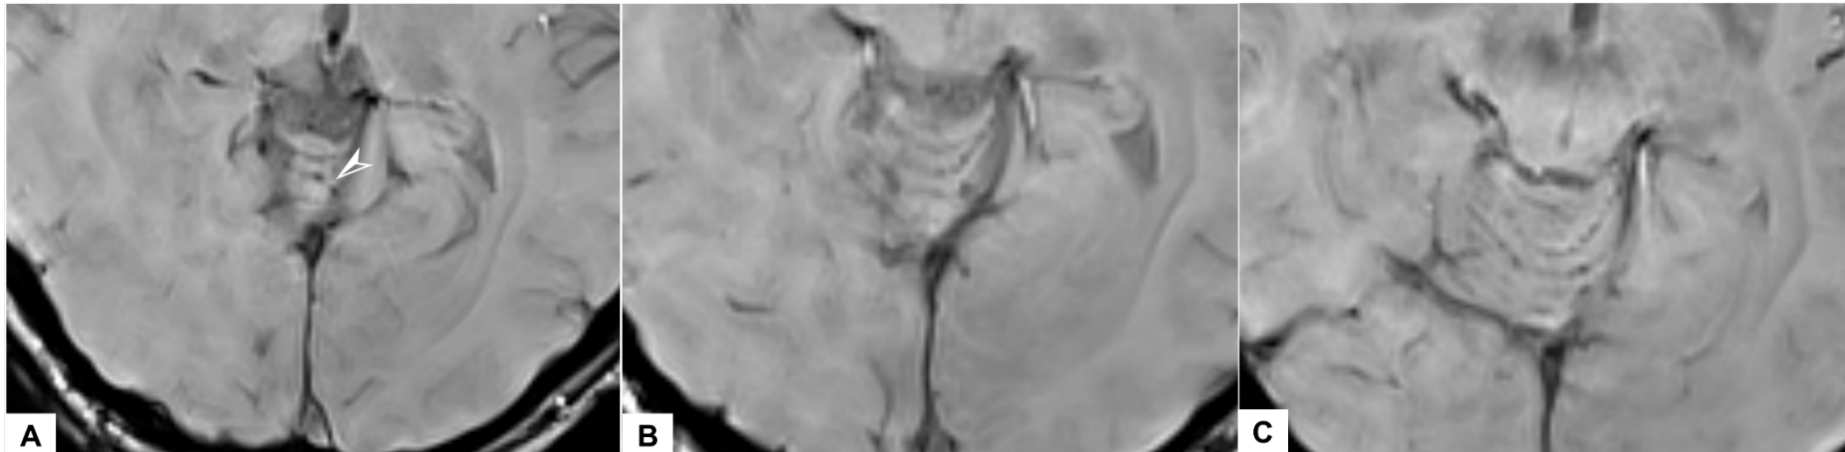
Axial susceptibility weighted magnetic resonance images of the case that was deemed equivocal. Here, the findings suggest presence of siderosis involving the left superior vermis only (A, arrowhead); A-C: cephalad to caudal images of superior vermis and cerebellar folia. Images: © UK Biobank.
